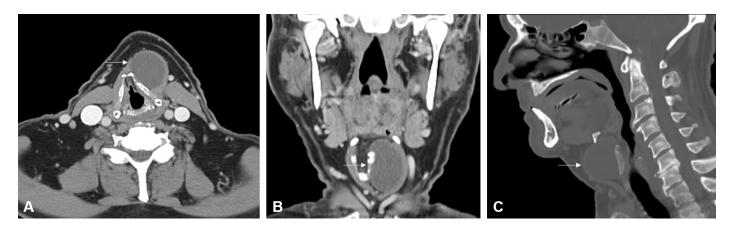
Contrast-enhanced computed tomography imaging shows a circumscribed hypodense cystic-like mass (white arrow) located just below the hyoid bone on (A) axial, (B) coronal, and (C) sagittal planes. The mass is located anterior to the left ala of thyroid cartilage and deep to the left thyrohyoid strap musculature in the left paramedian cervical region.
